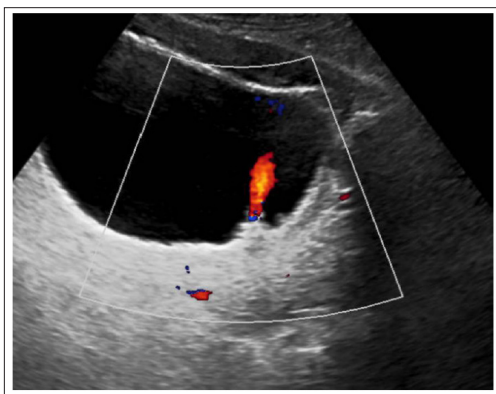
The lesion shows color doppler uptake indicating vascularized lesion
